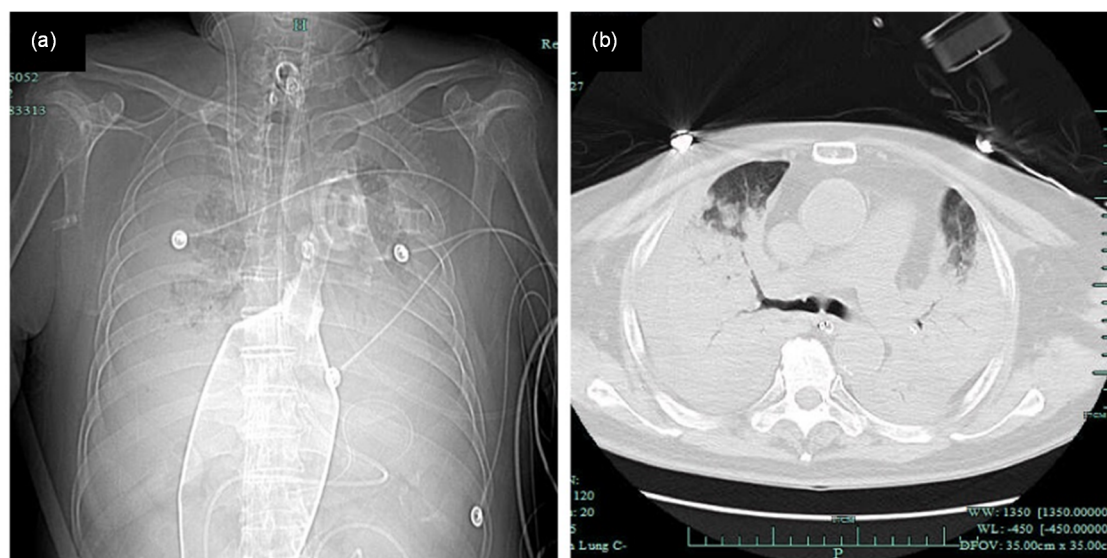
Severely diffused consolidation of the lung shown by chest X-ray (a) and computed tomography (CT) (b) scans
